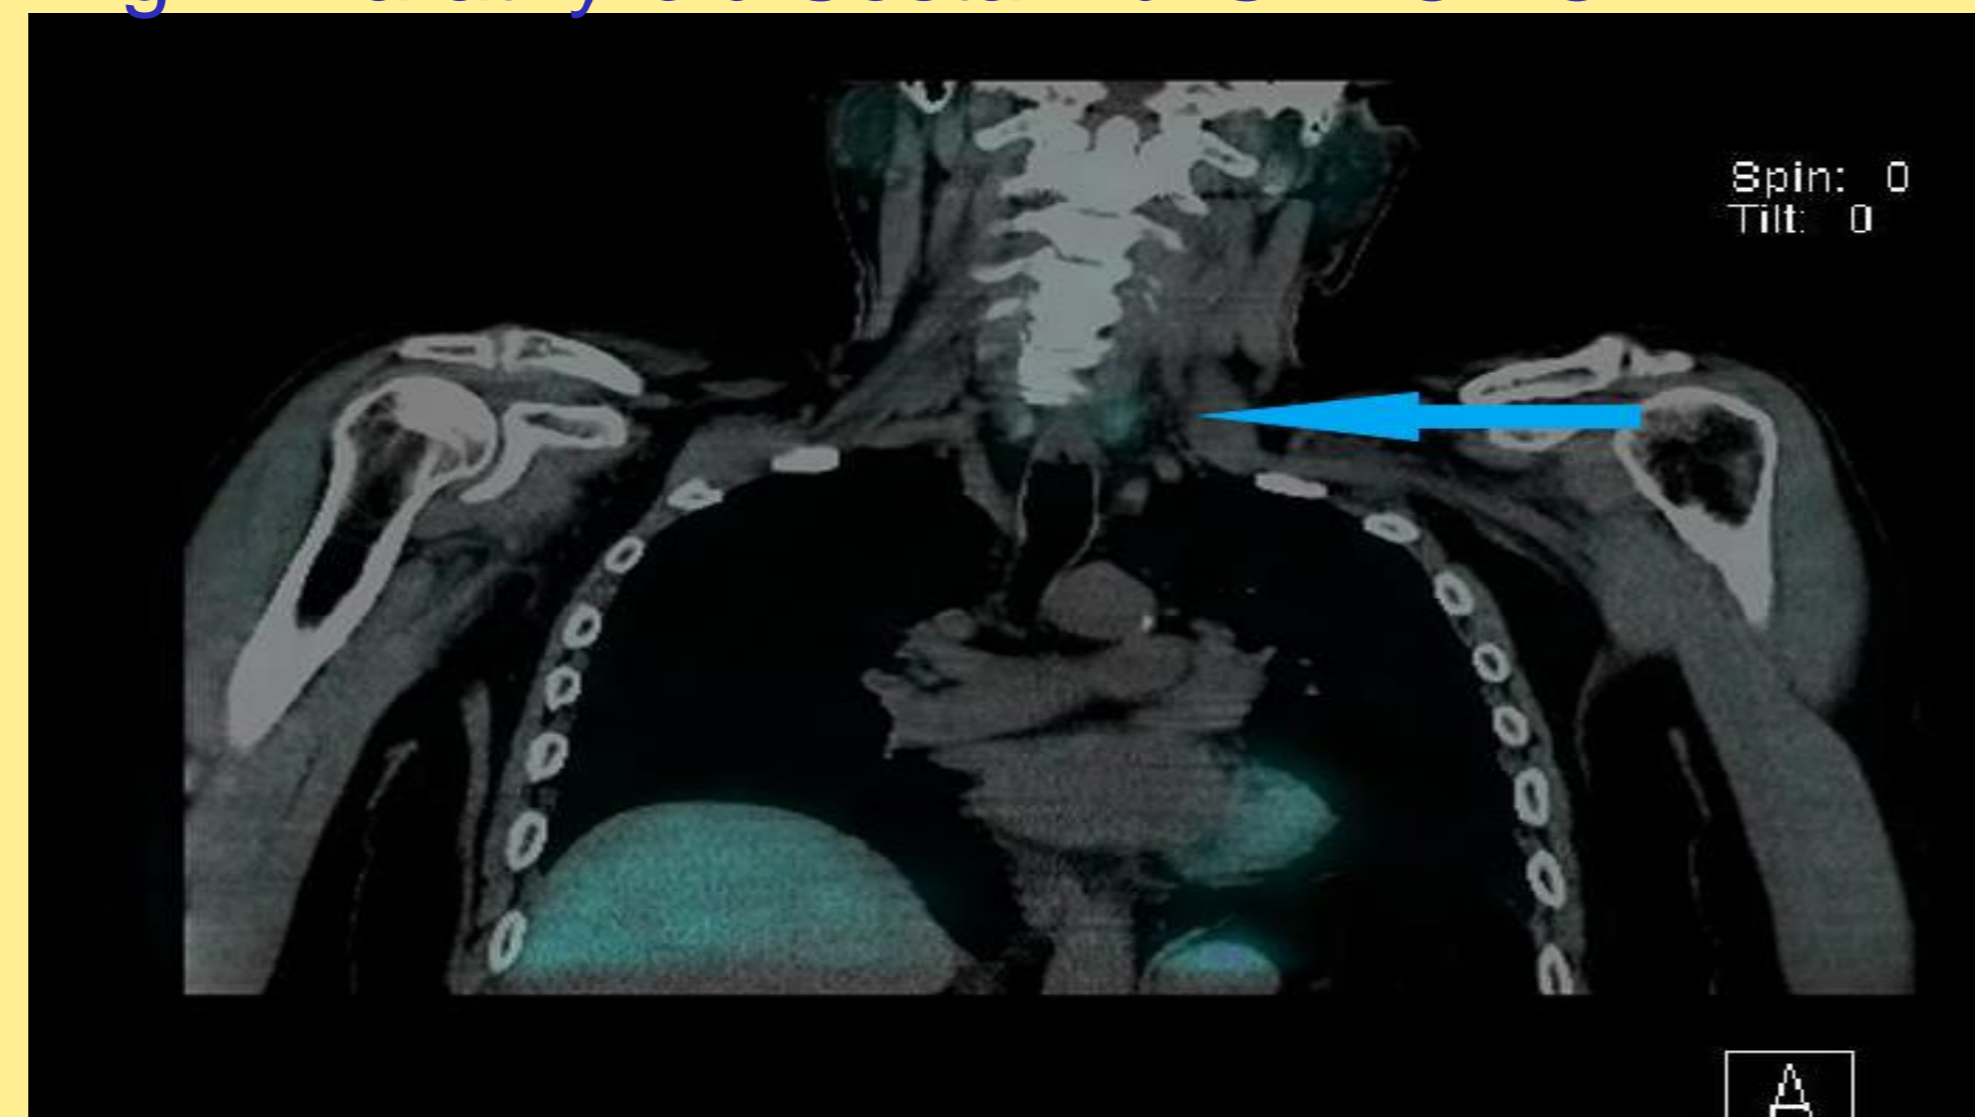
Ga68 DOTATATE PET CT (fused)
